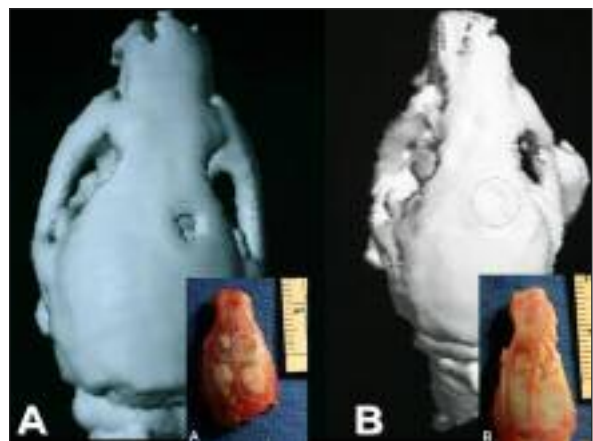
3D CT reconstruction images at the end of the fourth week demonstrating the calvarial defects (A) in G1 (marked by black circle) with partial closure and (B) in G2 after ABS administration with prominent defect closure (marked by black circle). Insets show relevant gross appearances of defect sites (marked by white circles).
